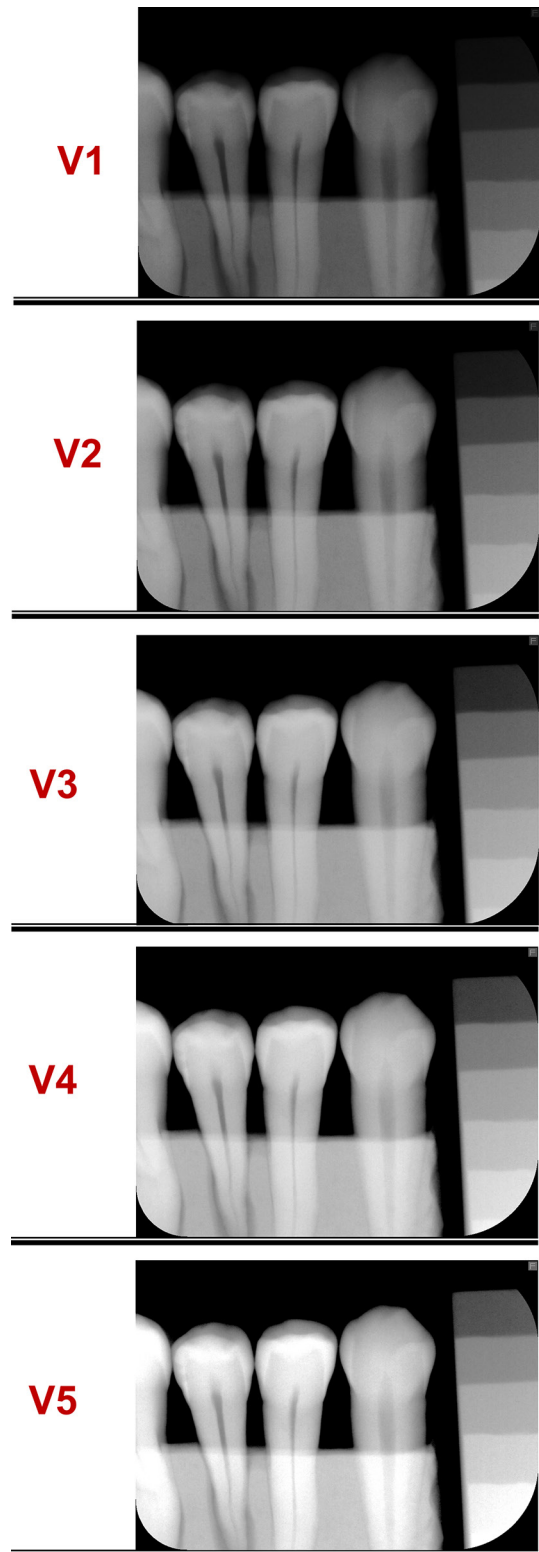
Radiographic images of the region of premolar teeth adjusted in the five brightness and contrast variations (V1–V5) showing caries lesions reaching only the enamel (mesial and distal surfaces of the first premolar) and a caries lesion reaching enamel and dentin (distal surface of the second premolar).
